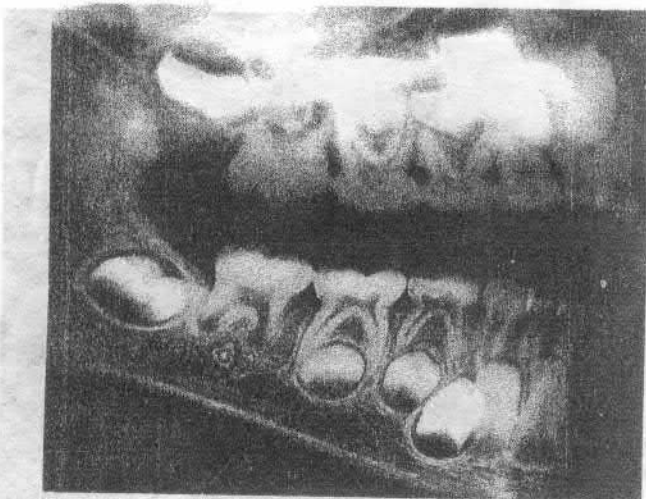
Radiography of maxillaries at the age of 2 years*
